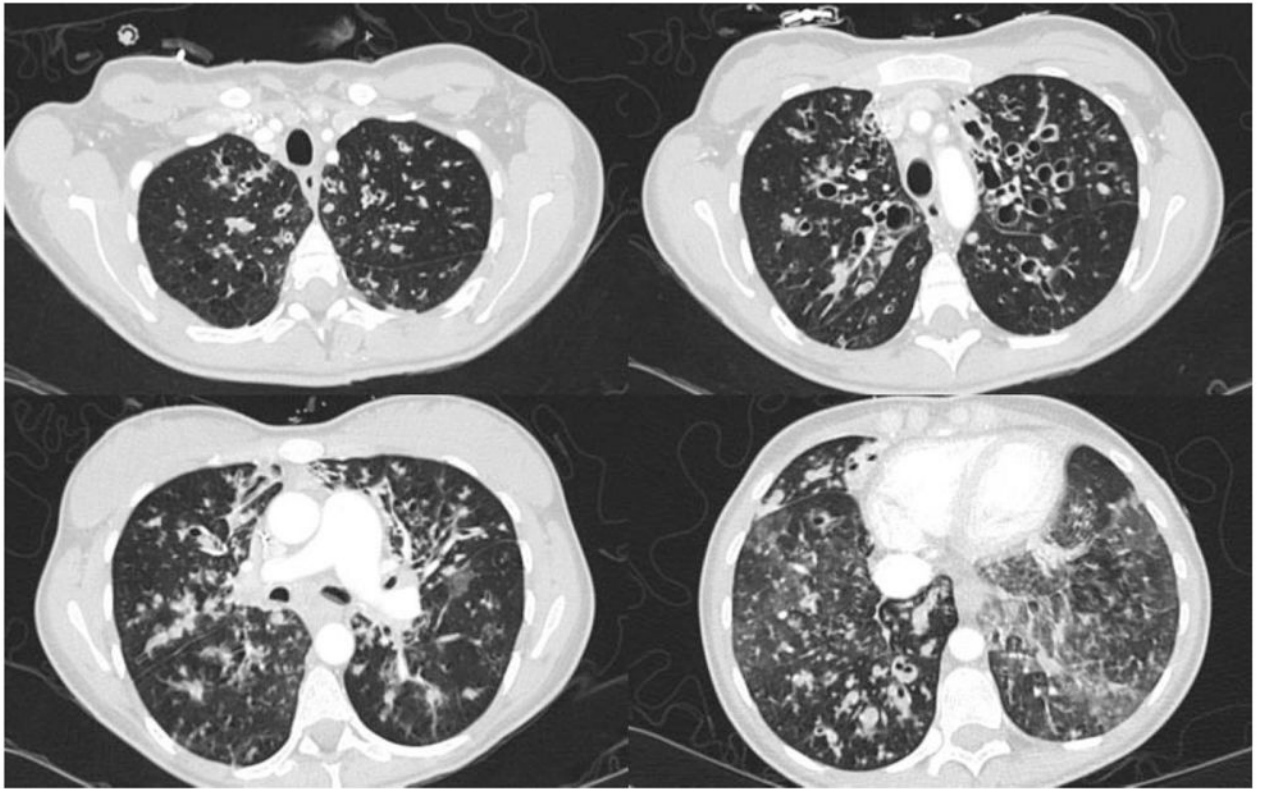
Contrast-enhanced chest CT of a 19-year-old woman with severe cystic fibrosis (CF) lung disease and invasive pulmonary *Aspergillus fumigatus* infection. She was hospitalized with a severe and ultimately fatal respiratory exacerbation while awaiting transplantation. The images reveal the bronchiectasis, mucus plugging, and air trapping that are typical of CF lung disease, as well as patchy opacities and tree-in-bud nodules that likely reflect radiographic manifestations of her acute exacerbation. Note that the main pulmonary artery (PA) is enlarged, and the patient did have secondary pulmonary hypertension with a PA systolic pressure estimated by echocardiogram above 60 mm Hg.
